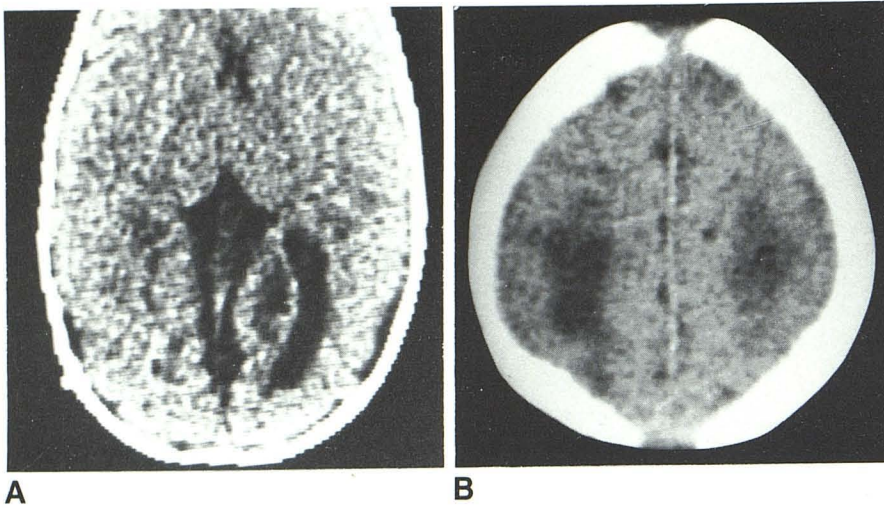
Late follow-up CT scans in two different patients show large cysts in occipital areas (A) and multiple small cysts in both cerebral hemispheres (B).
